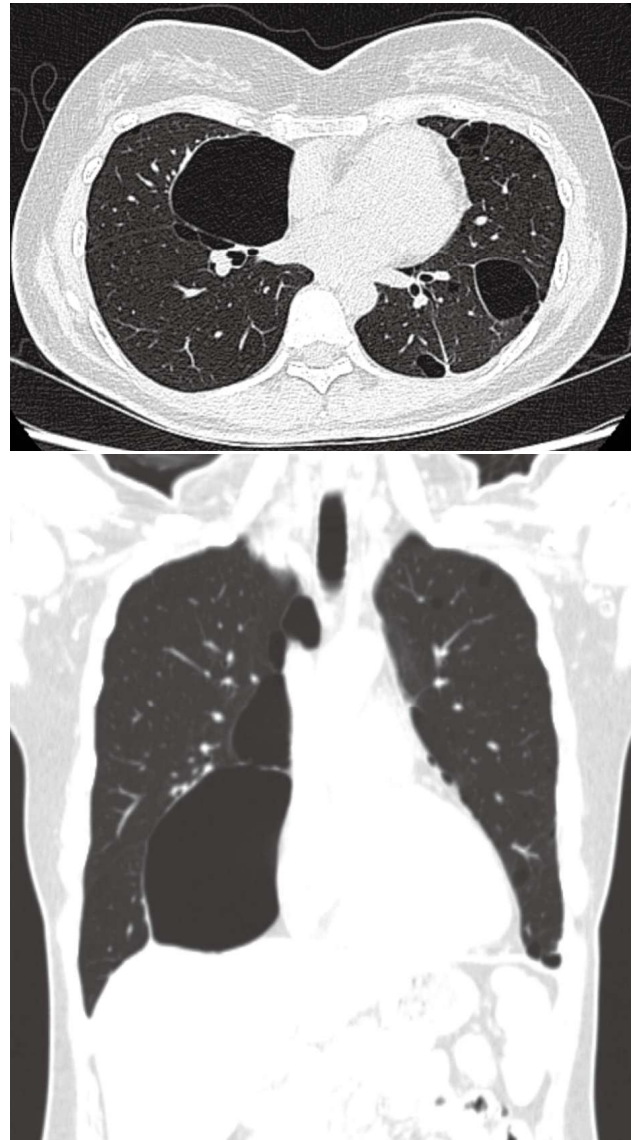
Chest CT showing multiple thin-walled pulmonary cysts predominantly in the basomedial lung. These findings contrast with the typical apical location of air blebs seen in patients with primary spontaneous pneumothorax or pneumothorax secondary to chronic obstructive pulmonary disease.
